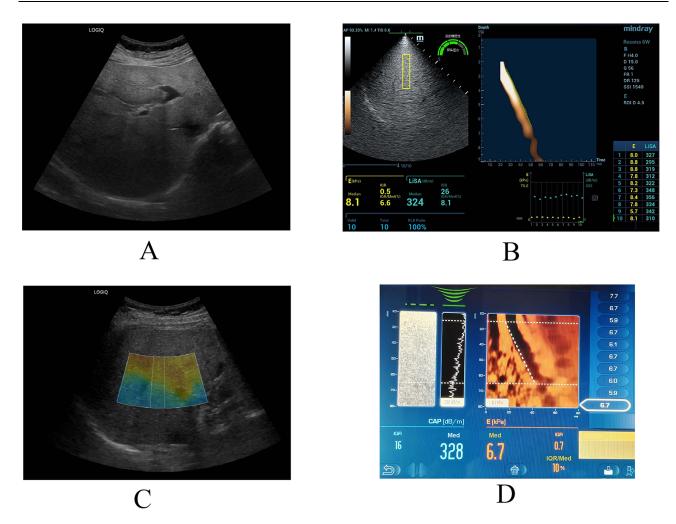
Figure I Examples of liver imaging results in a 63-year-old man with coronary heart disease. (A) B-mode ultrasound examination indicating severe hepatic steatosis. (B) LiSA measurement using the Mindray Resona 6w with a value of 324 dB/m. (C) UGAP measurement using the GE LOGIQ EII with a value of 327.58 dB/m. (D) CAP measurement using FibroScan with a value of 328 dB/m.
